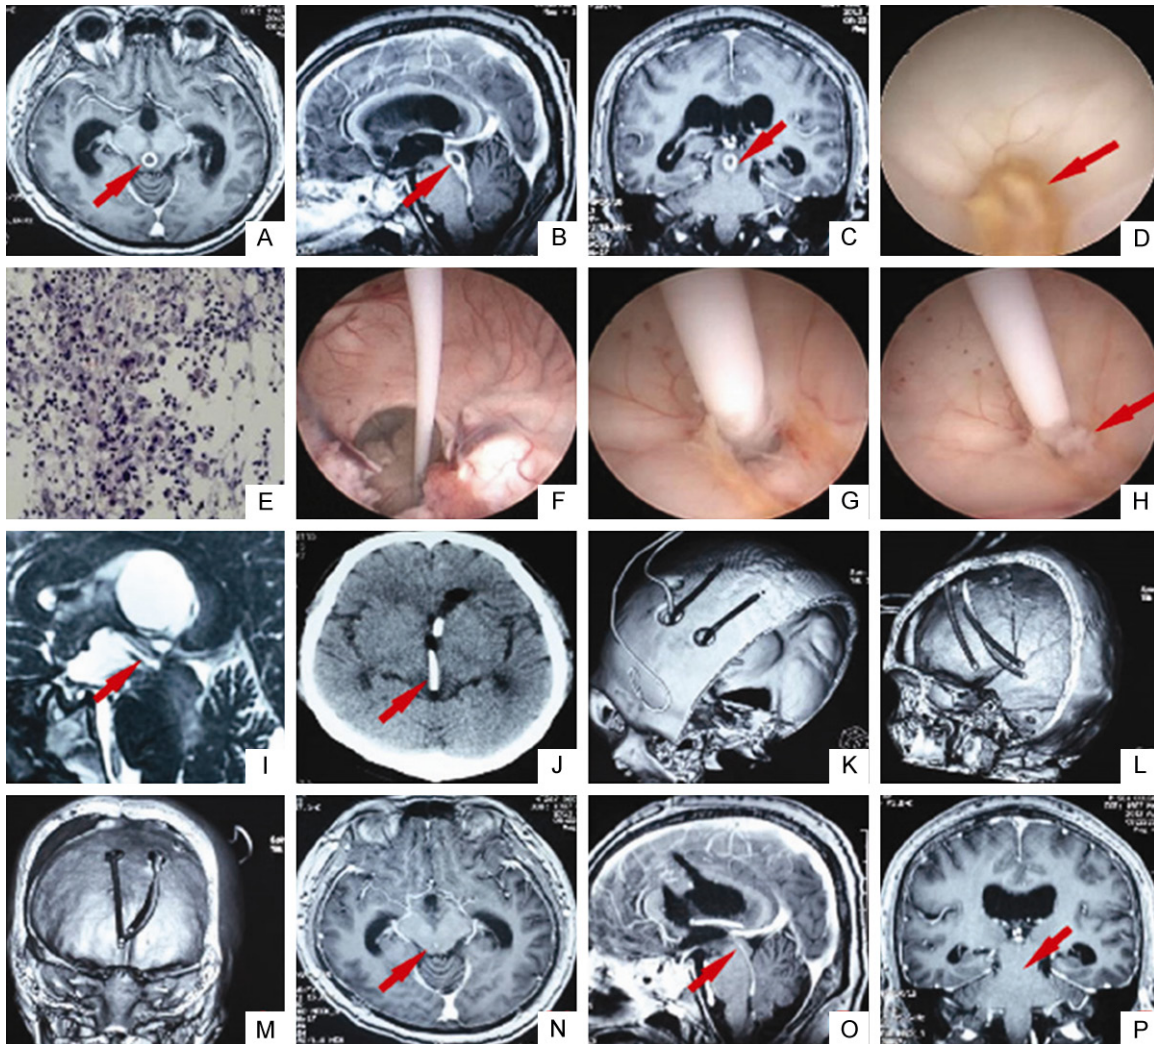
A-C: Enhanced magnetic resonance (MR) images showing abscesses in the midbrain aqueduct and the fourth ventricle, presenting as annular contrast enhancement in the midbrain aqueduct (red arrow), and narrowing fourth ventricle with linear contrast enhancement. D: Yellow tissue sediments observed in the ingress of midbrain aqueduct (red arrow). E: Pathological examination showing inflammatory cell infiltration. F: Implantation of drainage tube into third ventricle through the right foramina of Monro. G: Implantation of drainage tube into the abscess. H: Overflowing pus from the aqueduct following the infusion of antibiotic saline through drainage tube (red arrow). I, J: Magnetic resonance T2 weighted images and CT scan showing implantation of drainage tube into the abscess through the ingress of midbrain aqueduct (red arrow). K-M: Brain three-dimensional (3D) reconstruction CT showing the drainage tubes. N-P: Enhanced MR images showing the disappearance of the annular contrast enhancement in aqueduct and the residual linear enhancement in aqueduct and the fourth ventricle (red arrow).
